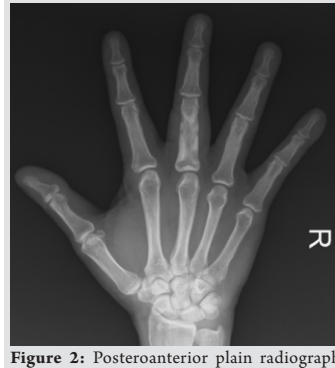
Posteroanterior plain radiograph increase bone density of proximal phalanx of third digit.
